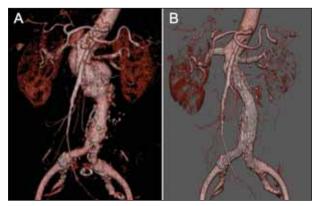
Preoperative three-dimensional CT scan (A). A follow-up CT scan shows complete exclusion, as well as preservation of the renal/visceral perfusion (B).
